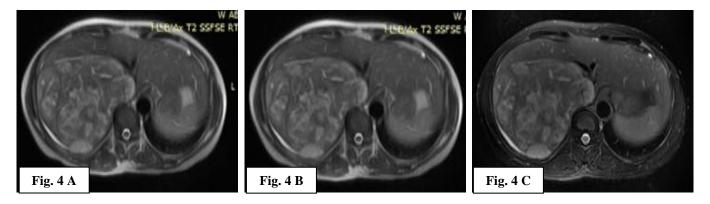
A, B, & C - MRI T2 fat suppressed axial views showing a large ill defined soft tissue lesion in right lobe of liver involving segment V, VI, VII and VIII displaying heterogenous signal intensity alterations and extending upto the capsule posteriorly and laterally. A separate feeder vessel was also noted.
